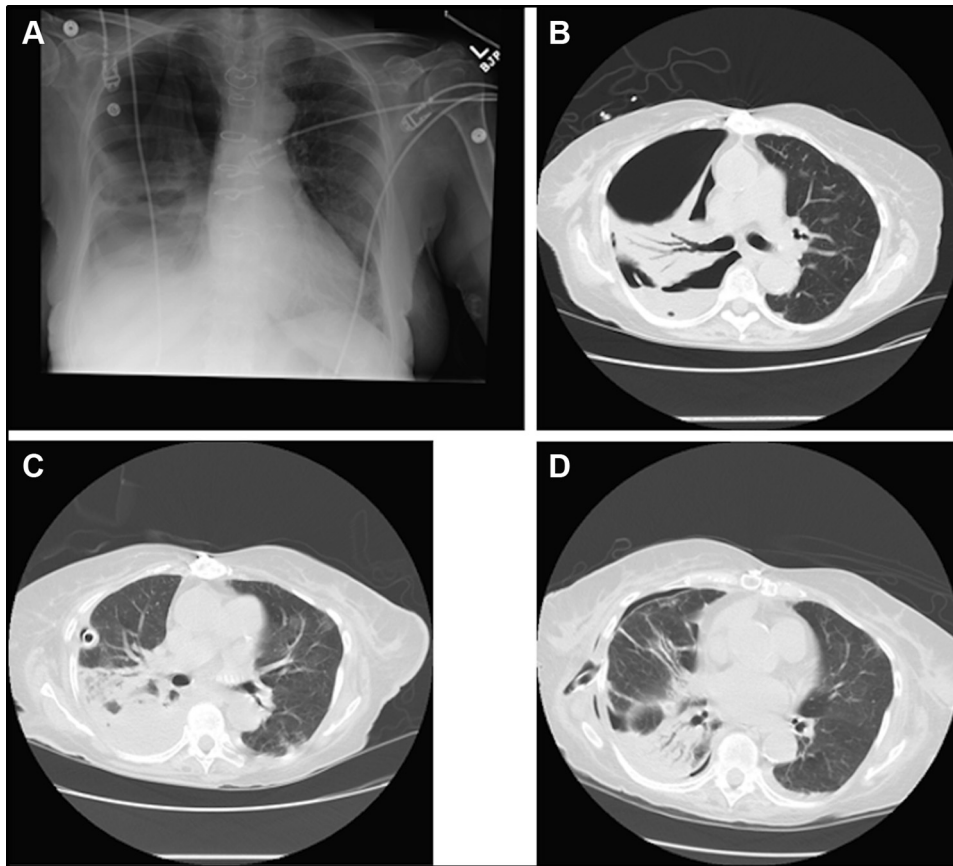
(A) Portable anteroposterior chest radiograph showing a large right pneumothorax with tethering of the apex of the lung to the chest wall. (B) Computed tomography (CT) of the chest on hospital day 1 shows large right hydropneumothorax with tethering of the lung to the chest wall. (C) CT scan of the chest on hospital day 7 shows marked decrease in the hydropneumothorax with persistence of middle and lower lobe consolidation. (D) Hospital day 10: decrease in hydro-pneumothorax with slight improvement in the amount of consolidated lung.
